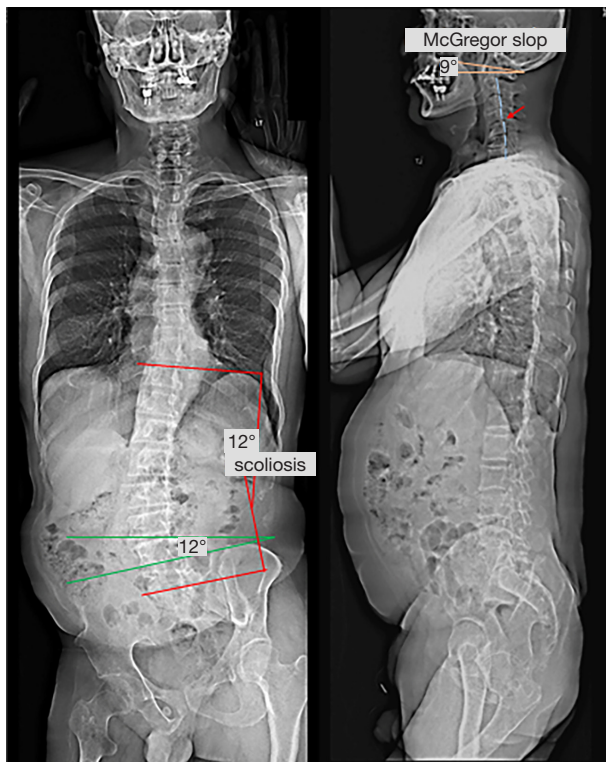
Comparing the result of 40-month treatment in the same patient shown in *Figure 1*. Repeat radiographs taken 40 months after the first one show patient's head ptosis has been corrected, the McGregor slop returns to 9° , and the majority of other radiographic parameters have improved. The coronal Cobb angle of the main thoracolumbar curve is 16° and pelvic obliquity angle is 12° .
